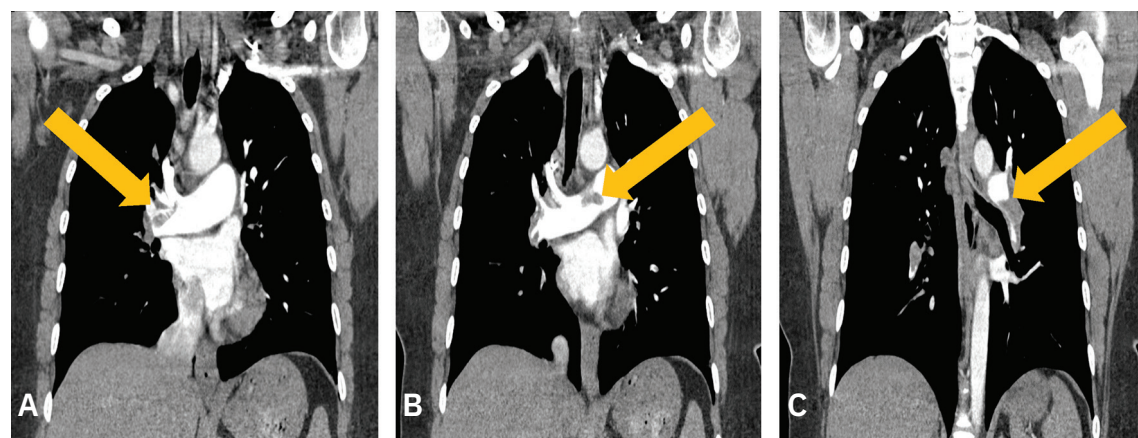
Submassive pulmonary embolism (PE) with lobar involvement shown across 3 computed tomography angiography (CTA) images.
